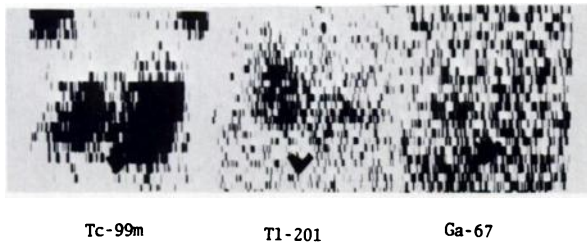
Sixty-two-year-old female with papillary carcinoma. Left: thyroid scan with pertechnetate (Tc-99m) reveals nodule with decreased activity in upper part of right lobe. Center: Tl-201 chloride scintigram reveals intense concentration in the nodule. Right: scintigram with Ga-67 citrate shows no accumulation.
